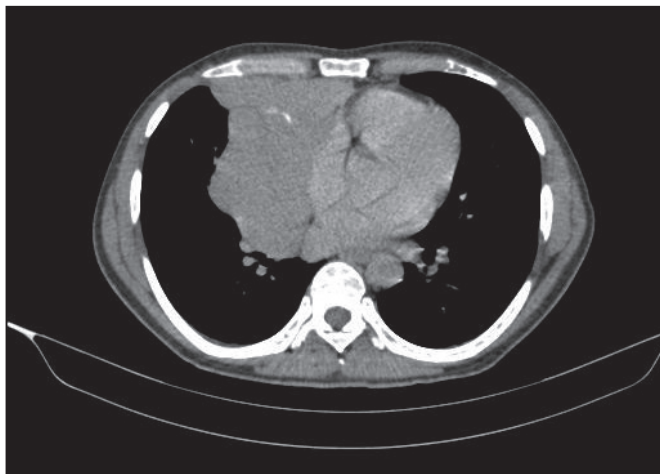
Chest CT revealed a large, irregular heterogeneously-enhancing soft tissue density mass lesion in the anterior mediastinum, predominantly on right side.
